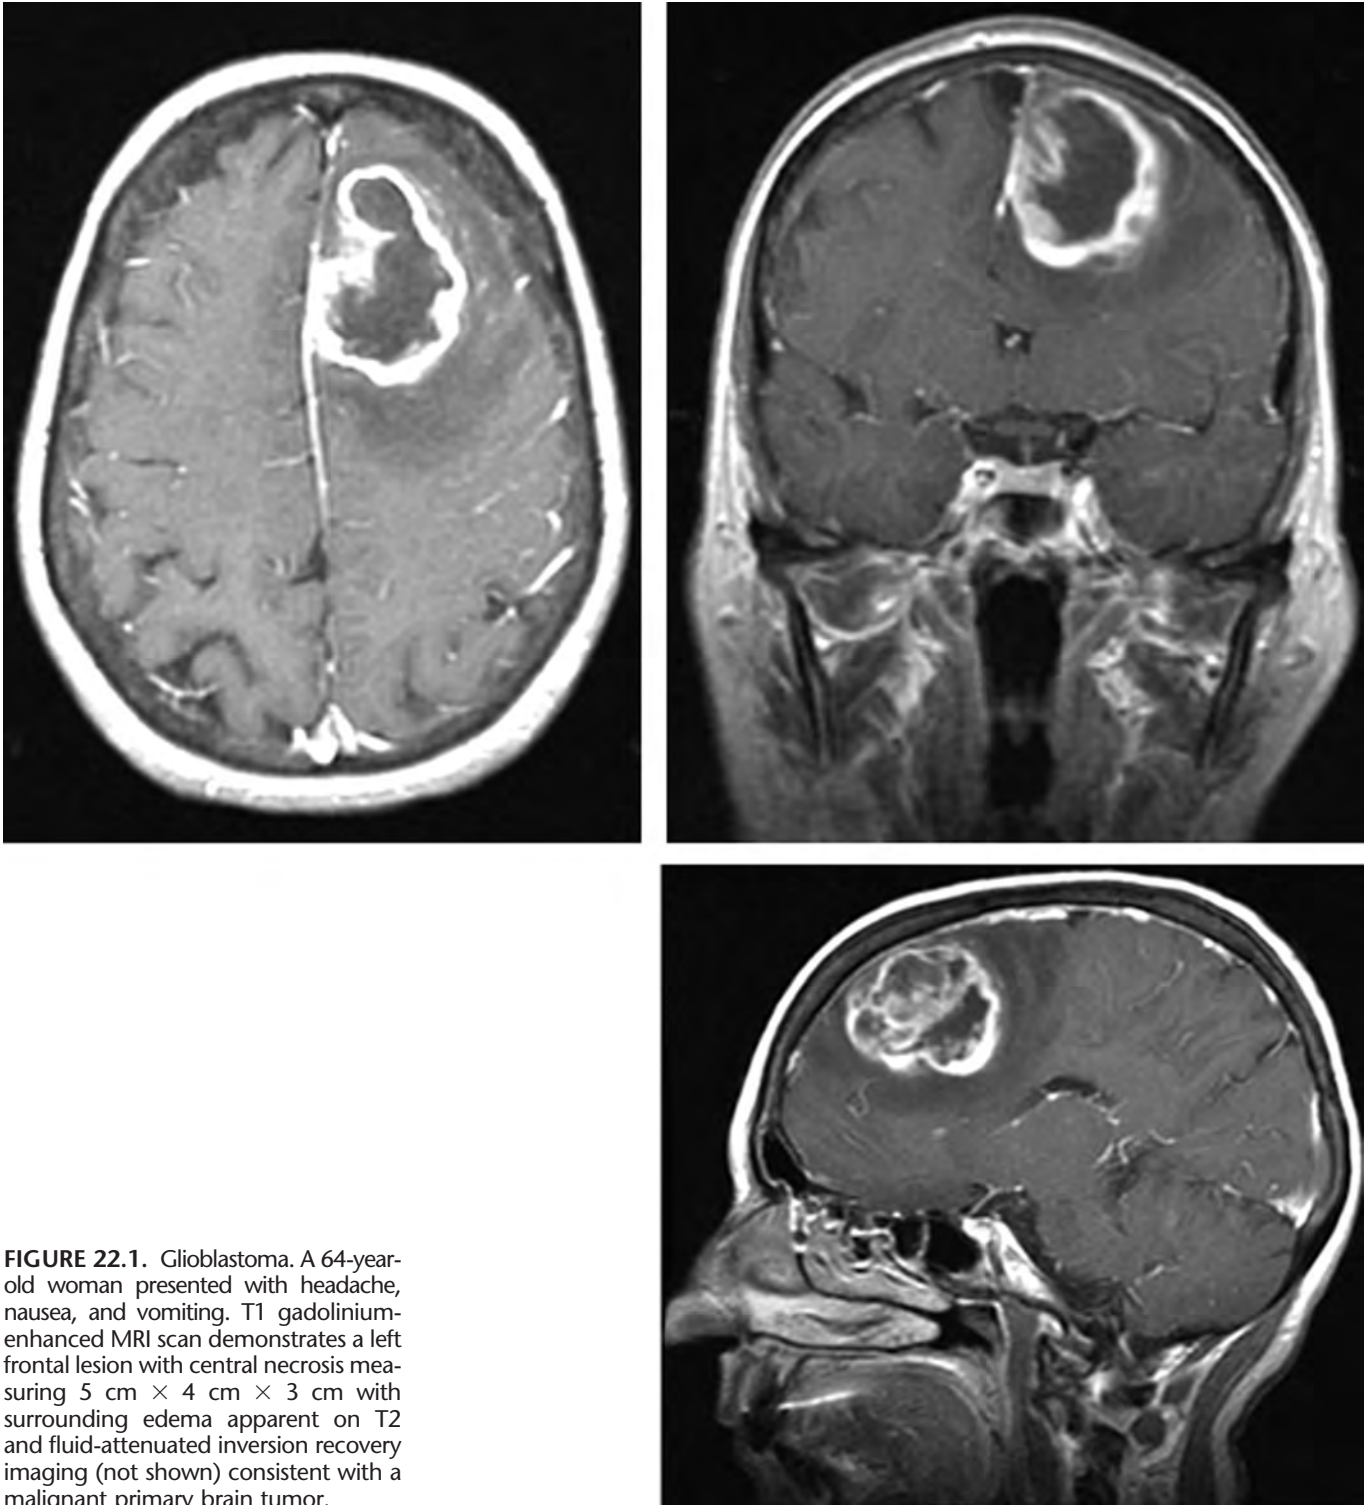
Glioblastoma. A 64-year-old woman presented with headache, nausea, and vomiting. T1 gadolinium-enhanced MRI scan demonstrates a left frontal lesion with central necrosis measuring 5 cm × 4 cm × 3 cm with surrounding edema apparent on T2 and fluid-attenuated inversion recovery imaging (not shown) consistent with a malignant primary brain tumor.
